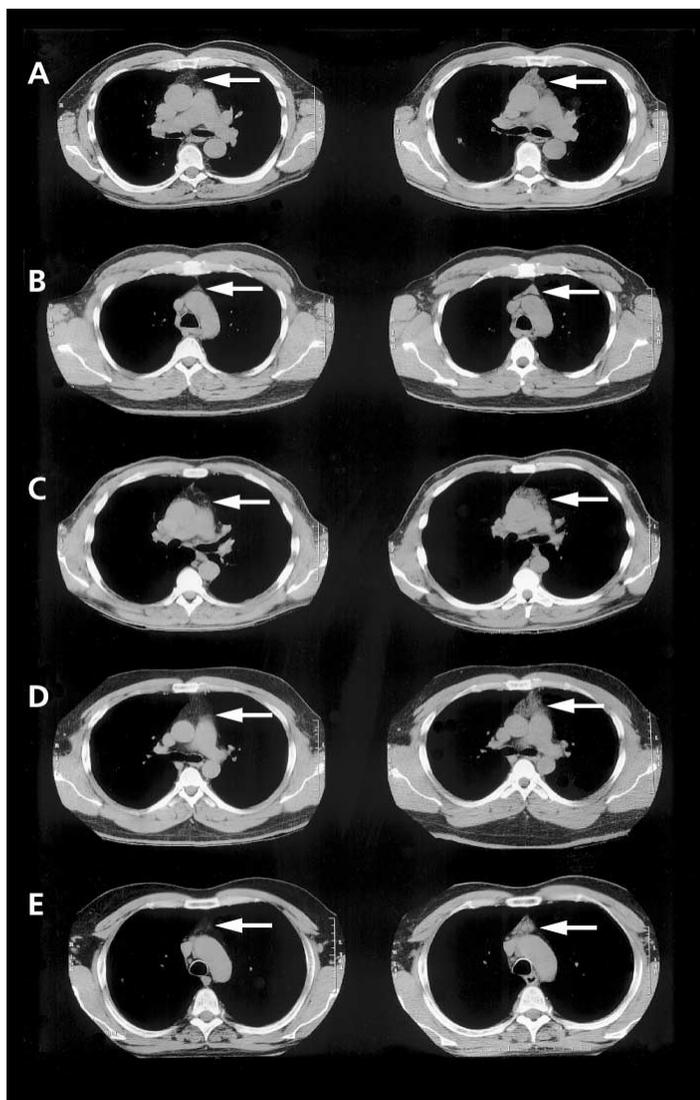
Reversal of thymic atrophy by growth hormone. Thymus computed tomography scans were performed at baseline and 6 months after initiation of growth hormone (GH) therapy in 5 GH recipients (A-E). Prior to GH treatment, the thymus (left column, indicated by an arrow) was seen as relatively low attenuation tissue, nearly black in color, consistent with fat density. After GH treatment (right column) the density of the anterior mediastinum markedly increased. The formerly black, fat-density tissue was replaced by higher attenuation tissue consistent with cellular thymus. Adapted with permission from Napolitano et al, *AIDS*, 2002.
